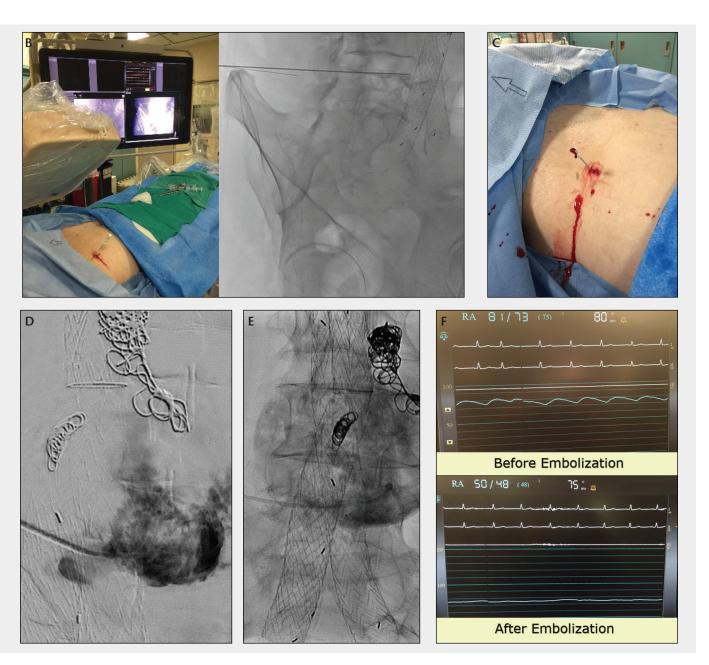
A patient with persistent type II endoleak despite previous embolization via a transarterial route. Translumbar direct sac puncture of the aortic sac is performed utilizing XperGuide software in conjunction with cone beam CT and fluoroscopic guidance (A). A 20-cm sheath needle is advanced into the endoleak sac until pulsatile arterial blood flow is noted (B, C). A contrast injection (saccogram) is performed through an access needle (D). Note that coils are from the previous embolization procedure. Because ingress and egress vessels are not easily visualized, thrombin was injected into the sac (E). Pressure measurement via the sheath needle demonstrates a decrease in pressure from 81/73 to 50/48 mm Hg after embolization, with loss of pulsatility (F).
